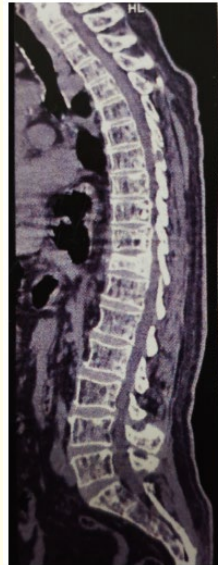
Sagittal CT scan image in parenchymal window without contrast injection revealing diffuse bone demineralization with a heterogeneous and multilocular appearance of the axial skeleton due to multiple layered lytic lesions, with a biconcave condensing compression of D11 reducing vertebral height by more than 50% without posterior wall collapse. This is associated with a stepped reduction in the height of several thoracolumbar vertebrae.
